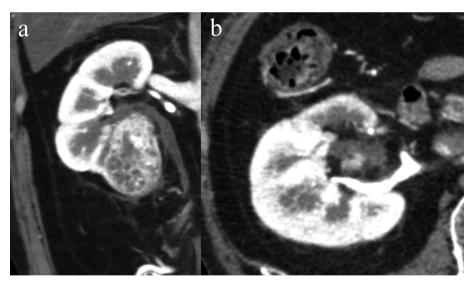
CT images after 25 months of sunitinib use.
